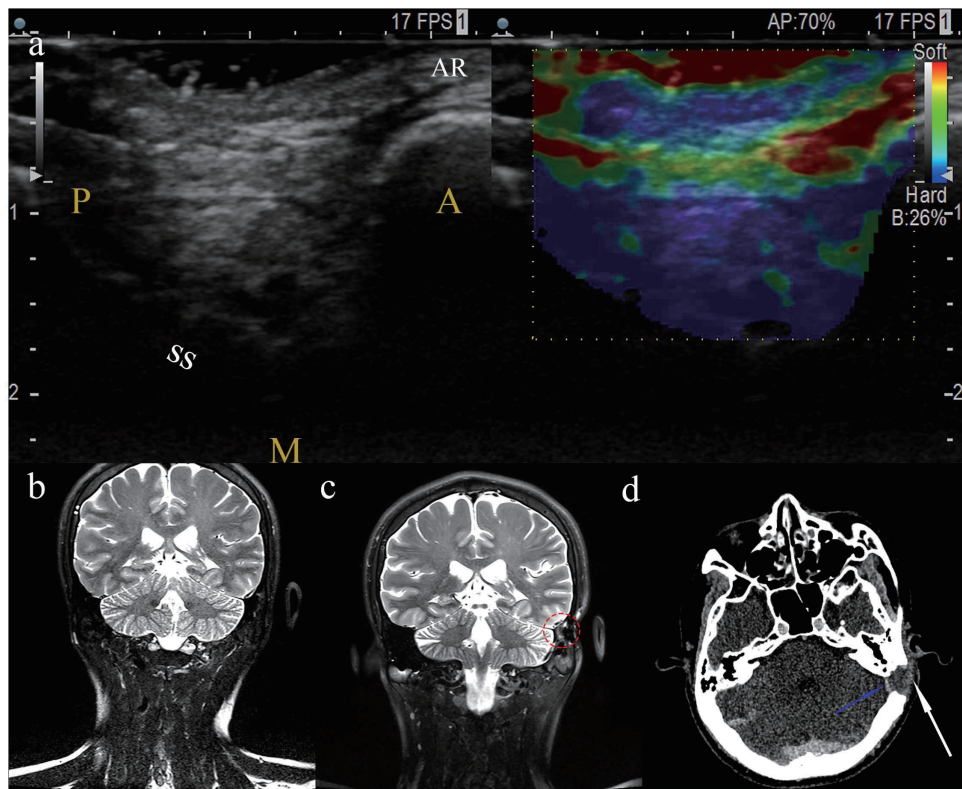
(Color online) (a) (left panel) Ultrasonographic B-mode view of postoperative retromastoid region with multiple clumps of gelatin sponge (GS) and N-butyl cyanoacrylate (GS-NbCG) combinations. A, anterior; P, posterior; M, medial; SS, sigmoid sinus; AR, the root of auricle. (Right panel) Elastographical view of the operative region. Note that this is solely an exploration, and a standardized technique to detect tissues and materials at this region has been lacking. (b) Preoperative and (c) postoperative T2-coronal magnetic resonance imaging exhibiting the operative application of GS-NbCG at the surgical site (red dotted circle). (d) Postoperative contrast-enhanced CT demonstrating the compression of the sigmoid sinus diverticulum (blue arrow) using multiple blocks of GS-NbCG (white arrow).
